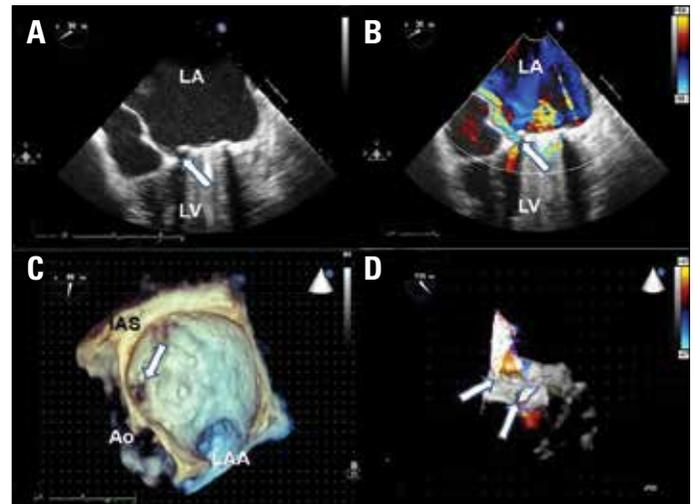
(A) 2D TEE revealed the PVL defect (arrow). (B) 2D TEE delineated the severe eccentric regurgitant jet (arrow). (C) 3D TEE revealed oval shaped PVL defect (arrow). (D) RT-3D TEE full-volume color Doppler examination permitted detection of two regurgitant jets (one large and one small; see arrows)
